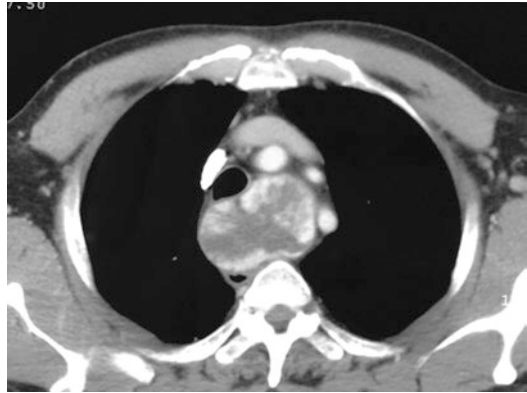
Voluminous posterior mediastinal goiter with tracheal, esophageal and great vessels dislocation. Axial plane CT scan after intravenous contrast administration
